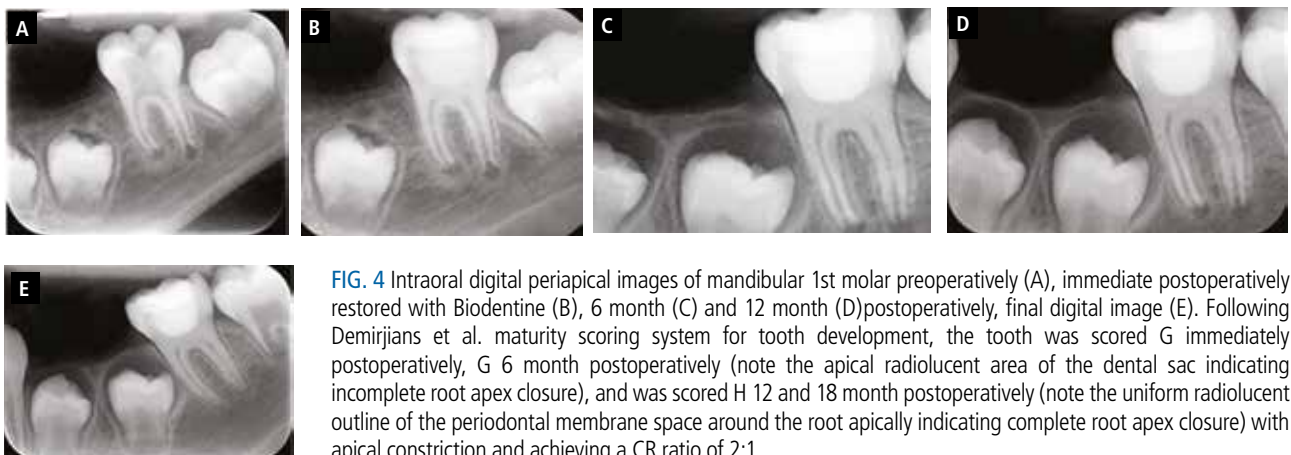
Intraoral digital periapical images of mandibular 1st molar preoperatively (A), immediate postoperatively restored with Biodentine (B), 6 month (C) and 12 month (D) postoperatively, final digital image (E). Following Demirjians et al. maturity scoring system for tooth development, the tooth was scored G immediately postoperatively, G 6 month postoperatively (note the apical radiolucent area of the dental sac indicating incomplete root apex closure), and was scored H 12 and 18 month postoperatively (note the uniform radiolucent outline of the periodontal membrane space around the root apically indicating complete root apex closure) with apical constriction and achieving a CR ratio of 2:1.
